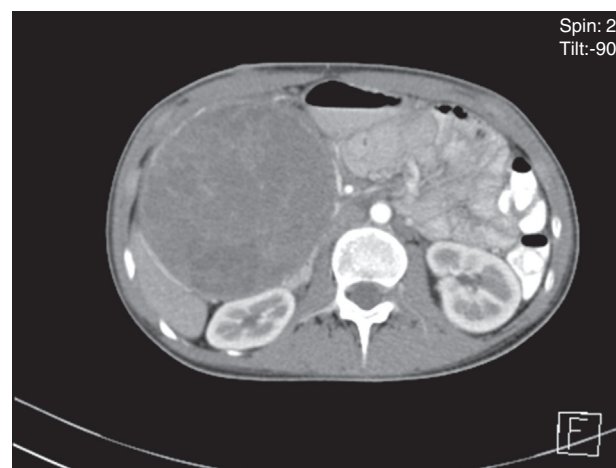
Abdominal computed tomography (axial plane, arterial phase): showing a mixed mass at the head of the pancreas.
